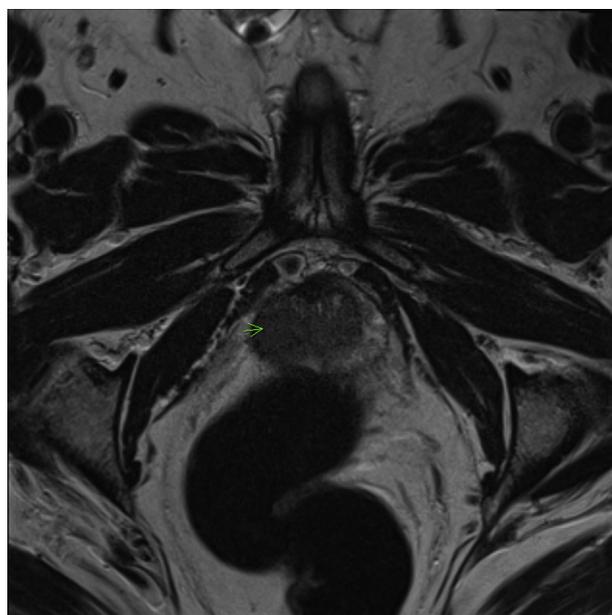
Axial T2-weighted magnetic resonance image demonstrating a PIRADS 5 prostate lesion.
